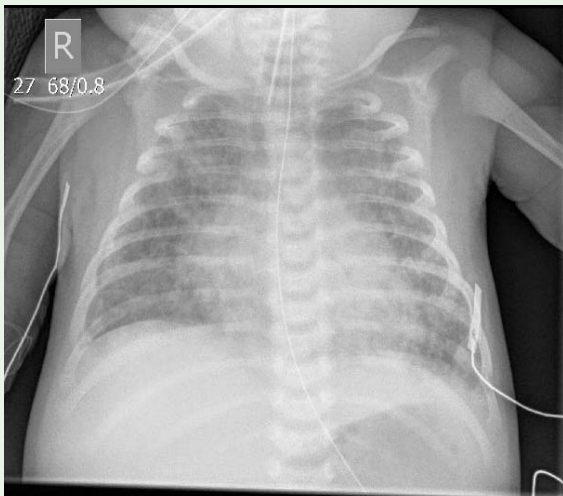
X-ray of the chest showing enlarged heart and increased pulmonary vascularity.
